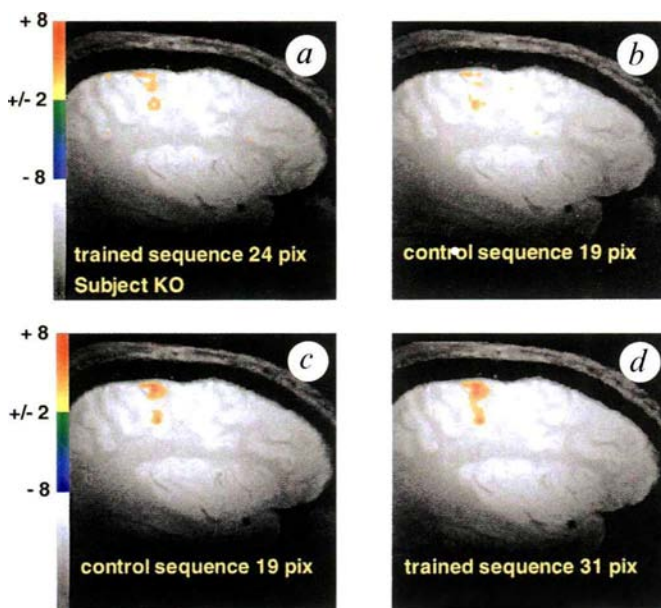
Differential evoked responses to the trained versus control sequence following 3 weeks of daily practice by subject KO on the designated training sequence, using his left hand; session 4. A parasagittal plane of section through the right hemisphere centred 35 mm from midline is shown; right, anterior; top, dorsal aspect of the brain. Activation maps from two sets (top and bottom) are shown superimposed on the corresponding structural MR image. Top, trained sequence performed first in the set (a) versus the untrained sequence performed second (b). Bottom, untrained sequence performed first (c) versus the trained sequence performed second (d). Z-score values are indicated by the pseudo-colour scale. The area of evoked response in M1 for the trained sequence was larger in extent irrespective of the order in which the sequences were performed. It did not, however, extend beyond the hand representation itself, as indicated by control experiments conducted in the initial and fifth session in 2 subjects, in which we mapped the evoked signal for each digit's flexion–extension movements, all four digits-to-thumb opposition, wrist extension–flexion, and eye (orbicularis oculi) closure (results not shown).
